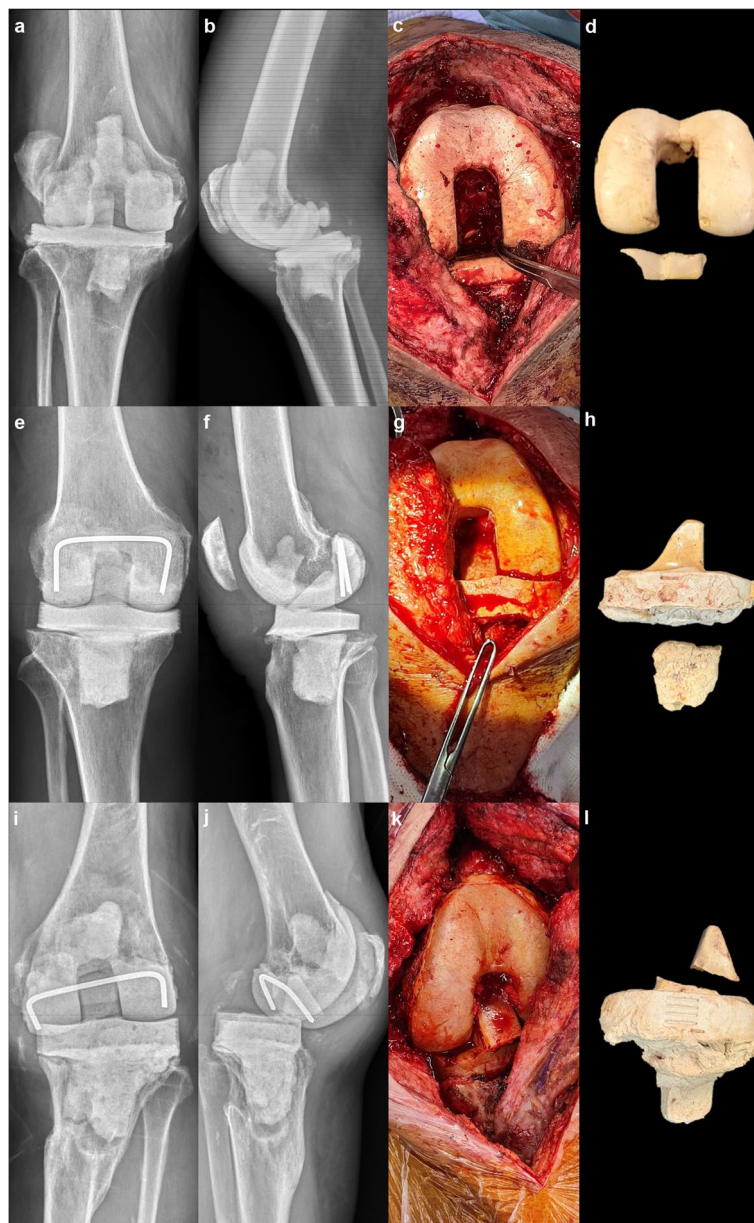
a-d. Mechanical complication 3 weeks after n-PS spacer use in a 77-year-old male. a Anteroposterior and (b) lateral radiographs of the knee showing an unstable joint after femoral cam fracture; c intra-operative view; d joint side view of retrieved femoral spacer and fractured cam. e-h. Mechanical complication 6 weeks after C-PS spacer use in a 64-year-old male. e Anteroposterior and (f) lateral radiographs of the knee showing tibial spacer dislodgement; g intra-operative view; h lateral view of retrieved tibial spacer and cement stem. i-l. Mechanical complication 6 weeks after C-PS spacer use in a 65-year-old female. i Anteroposterior and (j) lateral radiographs of the knee showing unstable joint after tibial post fracture; k intra-operative view; l lateral view of retrieved tibial spacer and fractured post
